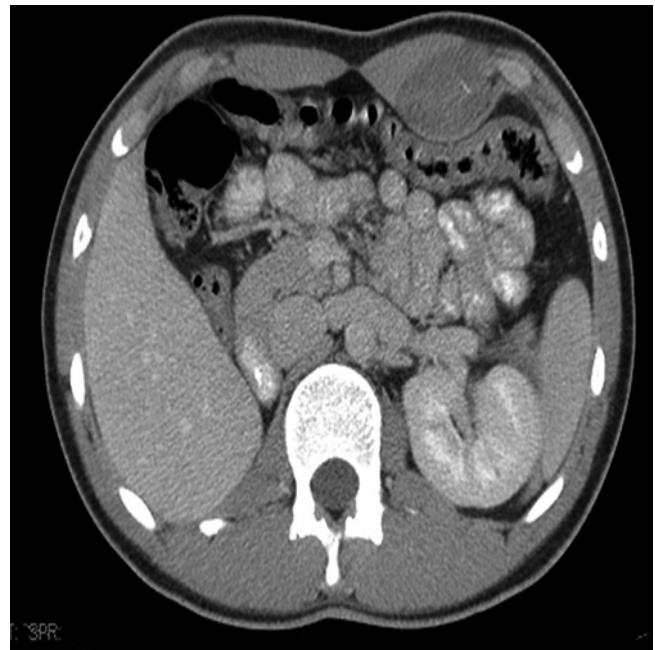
A 16 year-old boy presented with a painless bump on his left abdominal wall. A CT abdomen (shown here) demonstrates a 5.1×3.2 cm anterior abdominal wall mass. He underwent incisional biopsy followed by complete resection for synovial sarcoma
